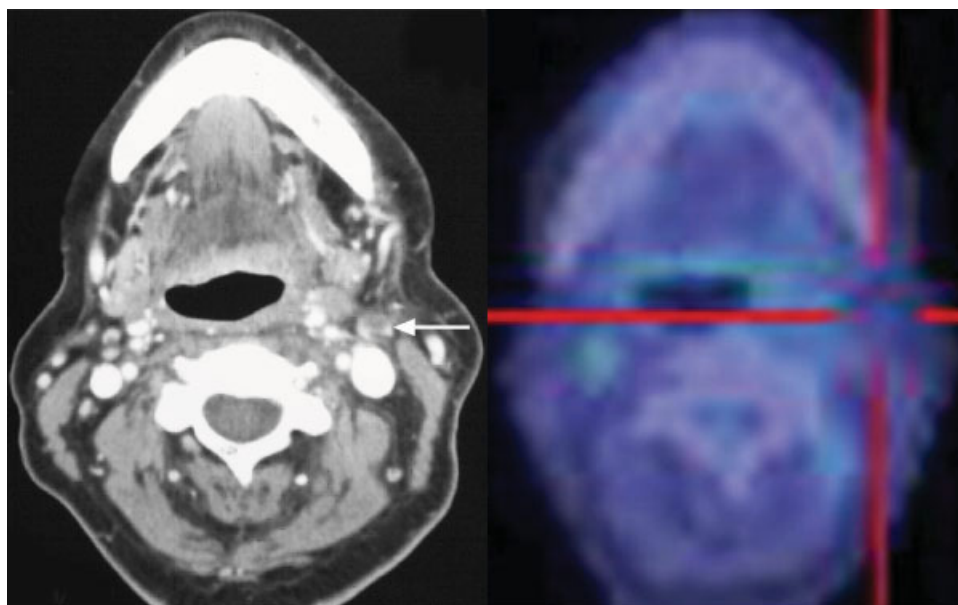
On the posttreatment CT, there was a residual enlarged cervical node, posterosuperior to L submandibular gland—measuring 12×8 mm (arrow). The pre- PET/CT plan was for neck dissection. The PET/CT fails to show any FDG avidity in the area of interest. This patient was therefore observed and remains alive and disease free at last follow-up.
